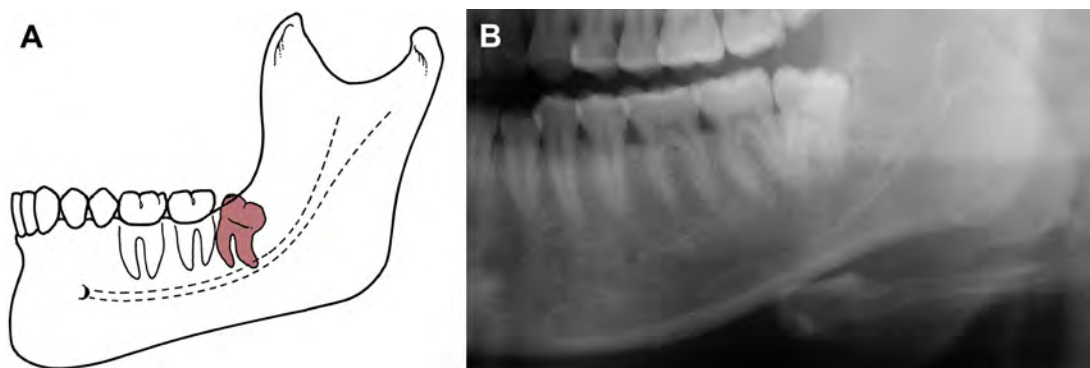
(A) Distoangular mandibular impaction—uncommon and most difficult to remove of the 4 types of mandibular third molar impactions. (B) Radiograph of distoangular impacted mandibular third molar. ([A] Adapted from Hupp JR, Ellis E III, Tucker MR, editors. Contemporary oral and maxillofacial surgery. 5th edition. St. Louis: Mosby Elsevier; 2008; with permission. Modified by Ion Syrbu.)
